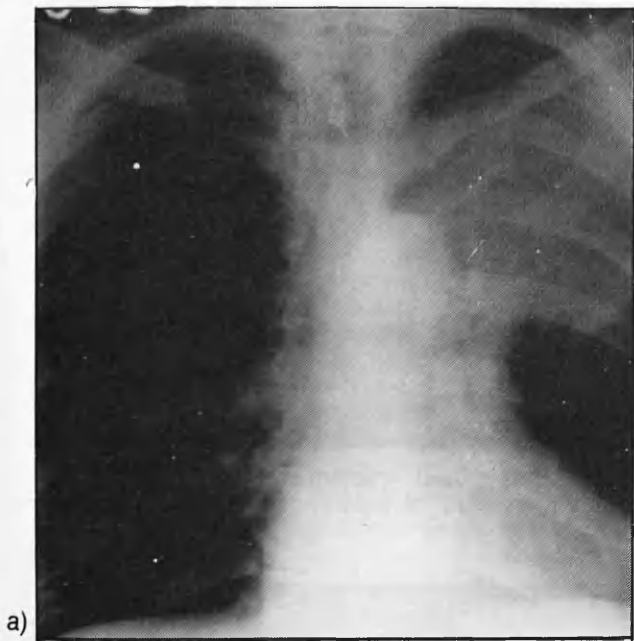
a) Chest X-Ray pre-therapy shows a large shadow in the upper zone of the left lung.
